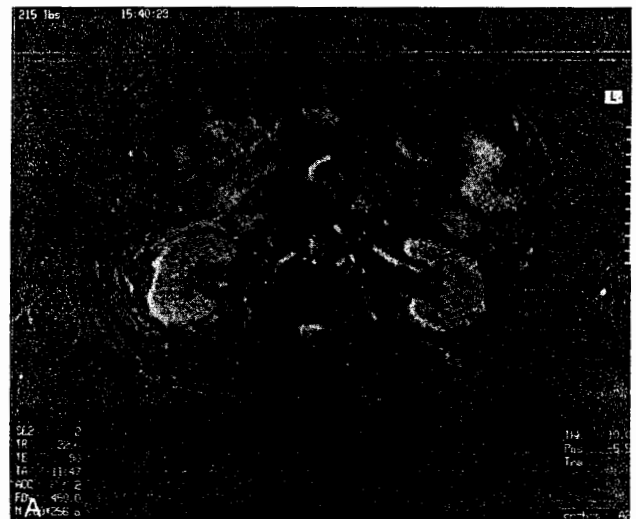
Same patient as in Figure 31-7. MRI studies using different parameter settings. In both *A* and *B*, gastrinoma (as in Fig. 31-7) is seen anterior and to left of aorta. In *B*, slender, darkly contrasting vein extends to the right from the gastrinoma.
